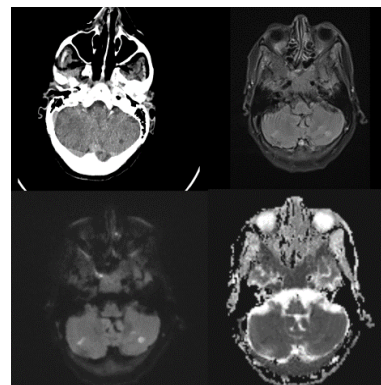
PICA territory infarct. Axial NCCT head (a) shows hypodensity in the left cerebellar hemisphere appearing hyperintense on T2 (b) and showing diffusion restriction on DWI (c) and ADC (d)
